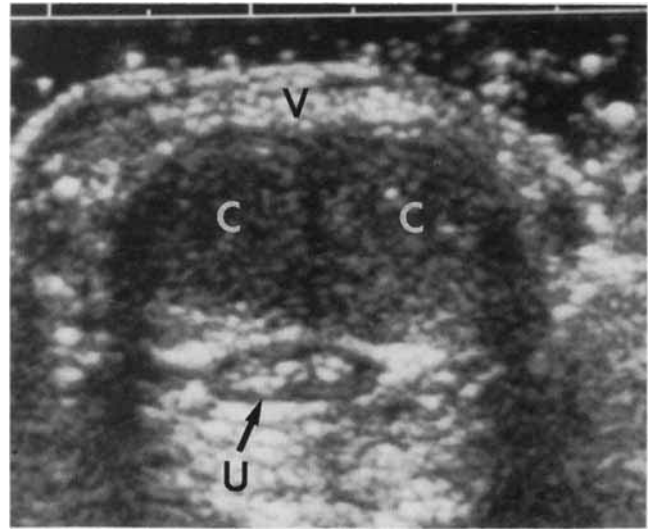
Ultrasound image of penis, cross-sectional view. Note abundant vascular soft tissue (V) superficial to paired corpora cavernosa (C) and urethral lumen (U).
